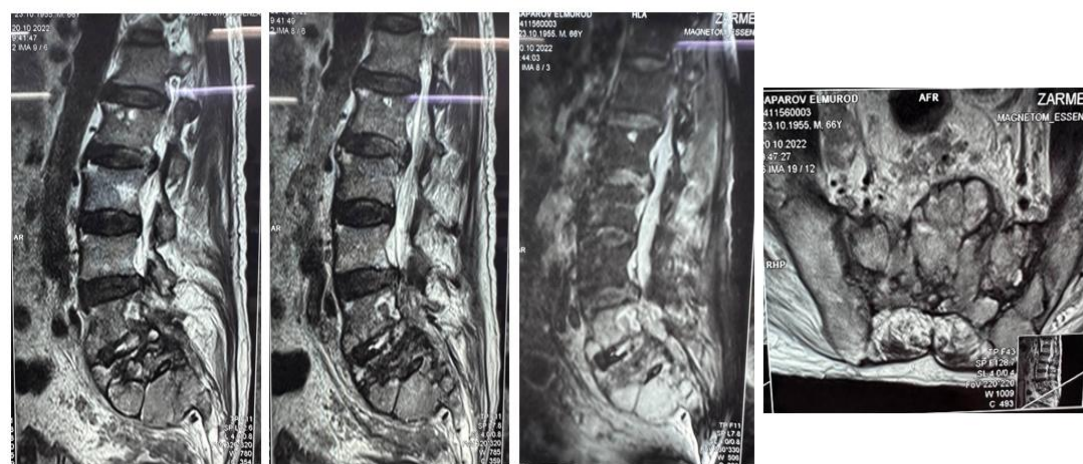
MRI images of the lumbosacral vertebrae
